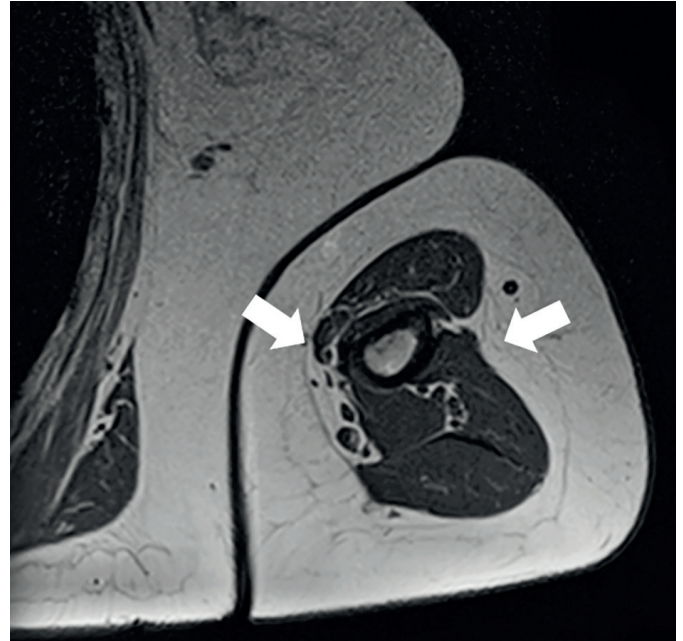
Axial MRI T1 weighted: Atrophy of arm muscles.
